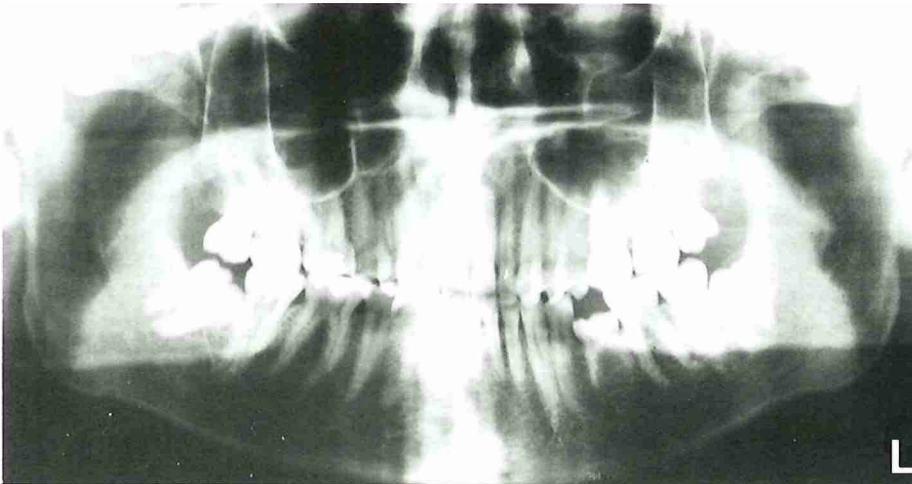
Orthopantomogram of a 25-year-old man showing secondary retention of the mandibular left second deciduous molar without a successor. No treatment was performed.
